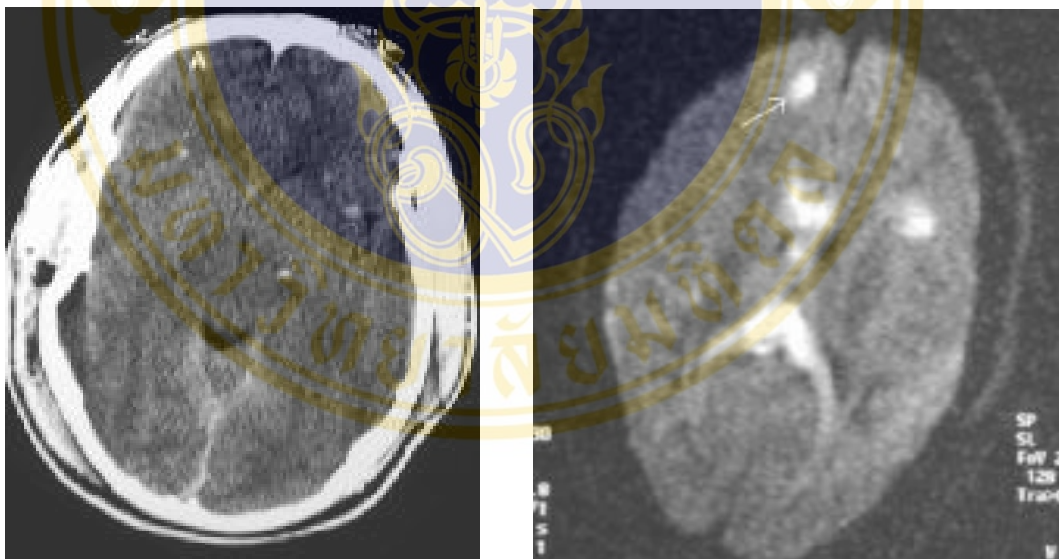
Non-contrast CT of a trauma patient demonstrates multiple petechial hemorrhages (arrows) consistent with diffuse axonal injury. Note that the hemorrhages are characteristically located at the gray-white matter interface. MRI diffusion sequence demonstrating multiple foci of abnormal increased signal at the gray-white matter junction (arrow) and within the corpus callosum in a patient with diffuse axonal injury.*
